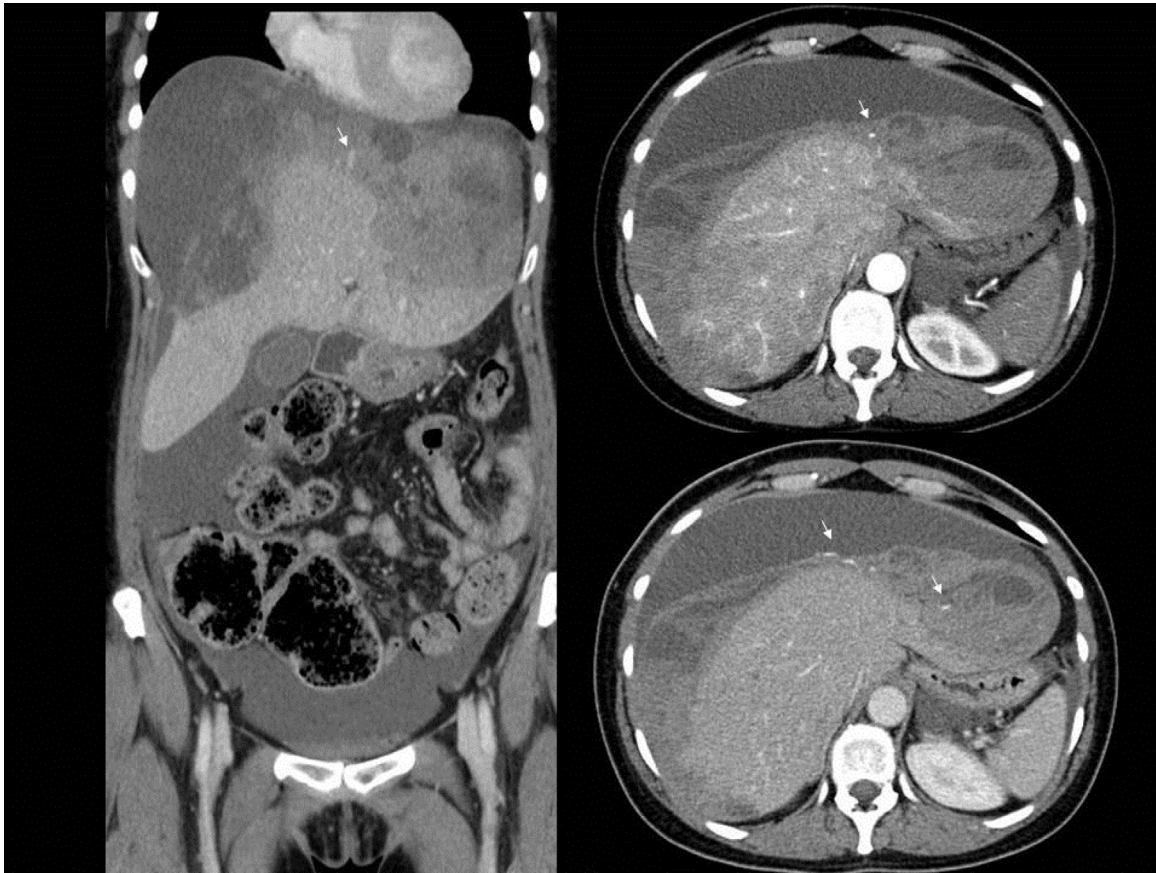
Coronal portal-venous phase (left) and axial arterial and portal-venous phase (right) CT images show a large subcapsular hematoma displacing liver parenchyma downward and backward. Spotty contrast extravasation is present (white arrows).
